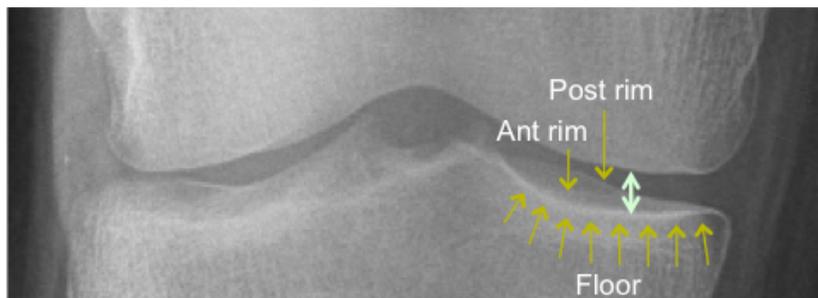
Optimal projection of the medial tibiofemoral joint space. The surface of the medial femur is convex, and thus projects as a sharp line regardless of the degree of flexion of the knee or angulation of the x-ray beam. The tibial plateau, however, is concave, and thus, the floor (row of arrows) of the plateau projects below the anterior and posterior rims (long arrows) when filmed with the X-ray beam aligned parallel to the tibial floor. Joint-space width is measured from the femoral surface to the floor of the tibia (two-sided arrow) not the rims of the tibia.
